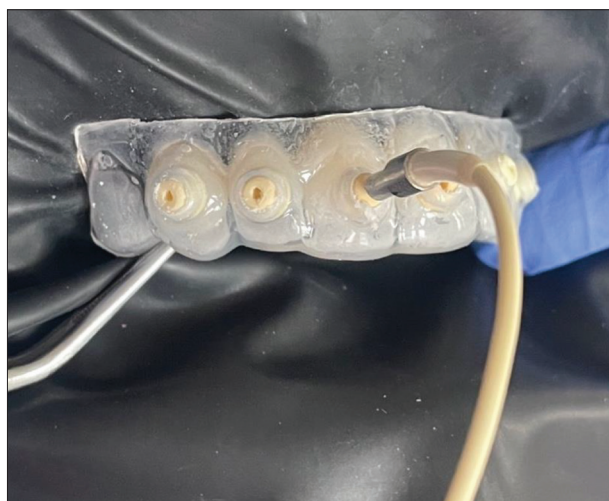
Laser Doppler flowmetry probe holder
